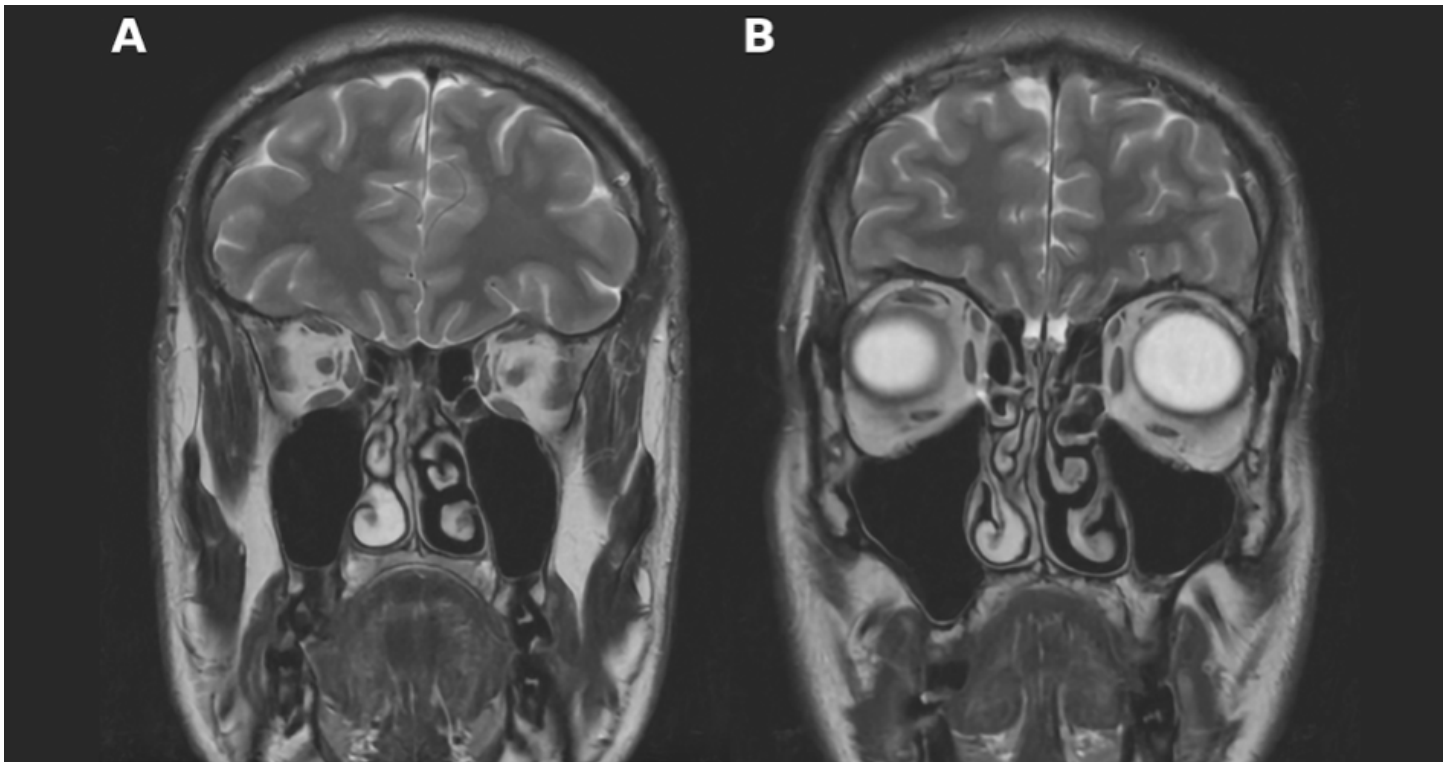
Coronal T2-weighted magnetic resonance imaging scans. A. Normal alignment of extraocular muscles in the unaffected right eye. B. In the affected left eye, nasal displacement of the superior rectus and inferior displacement of the lateral rectus are observed, supporting the diagnosis of Heavy Eye Syndrome.
